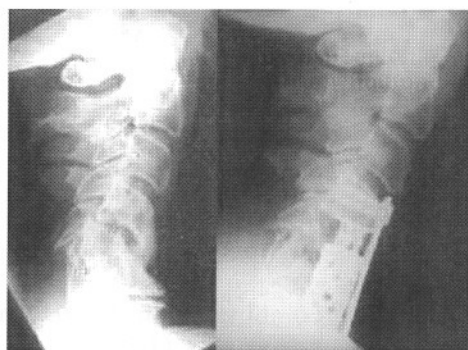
left: preoperative MRI cervical stenosis after laminectomy 12 years ago with myelopathy and syrinx, right: postoperative MRI with implant ADD.
